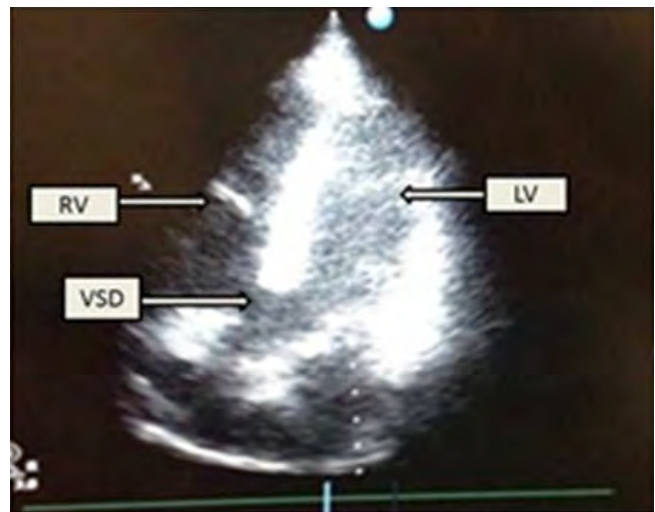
Echocardiography revealed a large VSD which lay beneath the dilated aorta, hypertrophied right ventricle. LV: Left ventricle, RV: Right ventricle, VSD: Ventricular septal defect.
